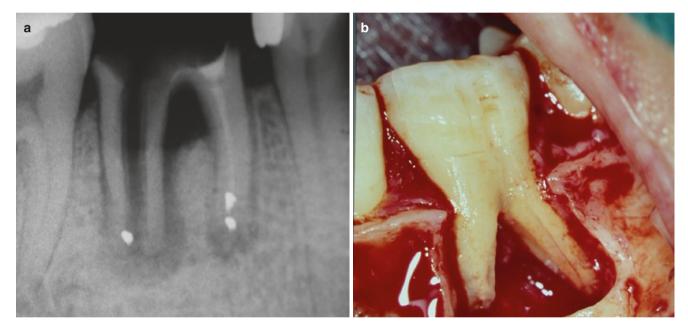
Vertical root fracture involving lower molars. (a) Dental radiography of the lower molar after apicoectomy and retrograde root filling with vertical fracture involving the distal root. (b) Vertical fracture of the distal root of the first molar detected after the MPF has been raised
